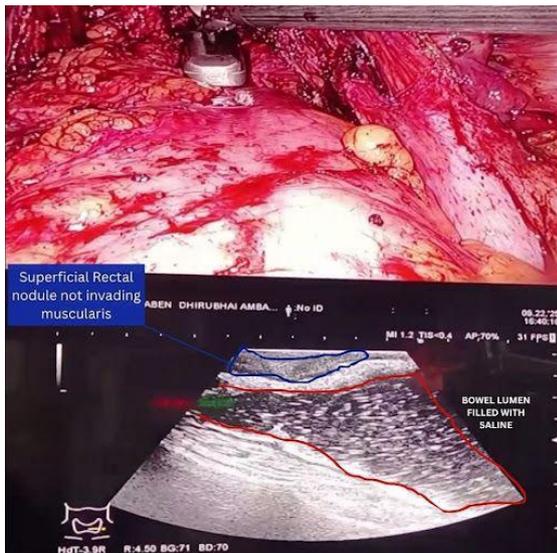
Intraoperative, robotic integrated ultrasound image with simultaneous view during surgery showing a superficial rectal nodule, not invading muscularis
